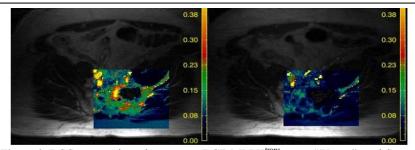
RCC metastasis to the sacrum. DCE-MRI K^{trans} maps ("Vp-on" model), are shown before (left) and after (right) treatment with Sunitinib. K^{trans} response was 76%, with median pixel values of 0.15 min⁻¹ (pre-Tx) and 0.03 min⁻¹ (post-Tx).
